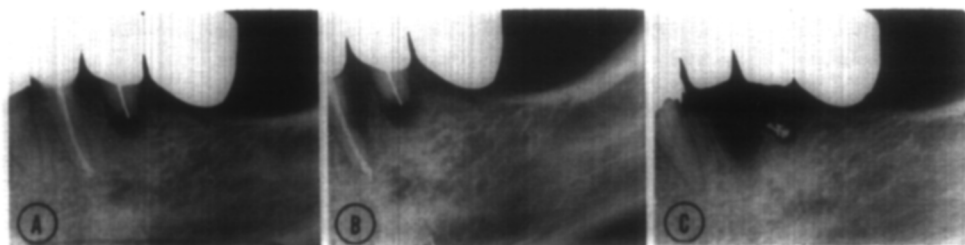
Case 155 (same case as in Fig. 7). *A*, Radiograph showing tooth No. 29. Two months after obturation with silver cone, patient presented with a fistula and no pain. *B*, Postoperative radiograph after periapical curettage of tooth No. 29 and periodontal curettage of distal surface of tooth No. 28. *C*, Postoperative radiograph 2 months later, after teeth 28 and 29 were extracted because of progressive periodontal disease.
